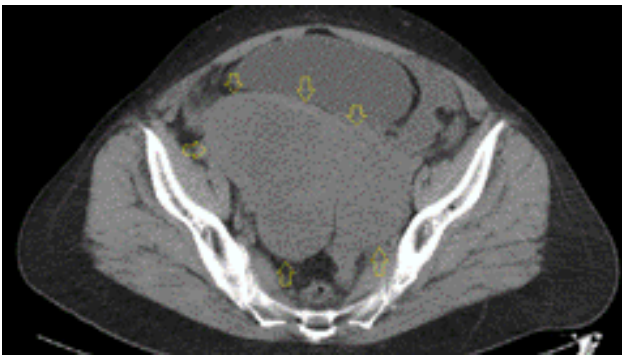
Axial CT view of malignant peripheral sheath nerve tumor (lesion is indicated by yellow arrows)
